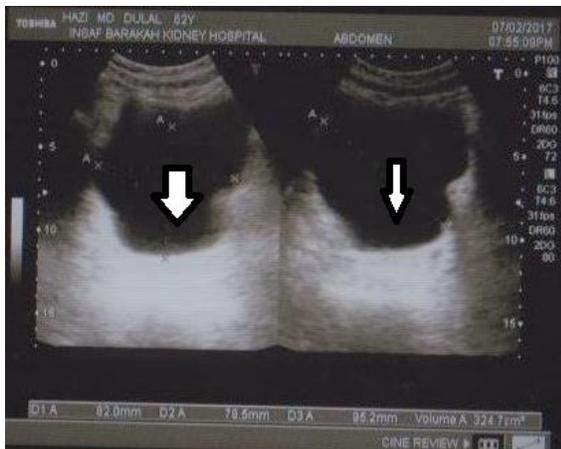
Ultrasonography of left kidney (arrow) reported as hydronephrosis
